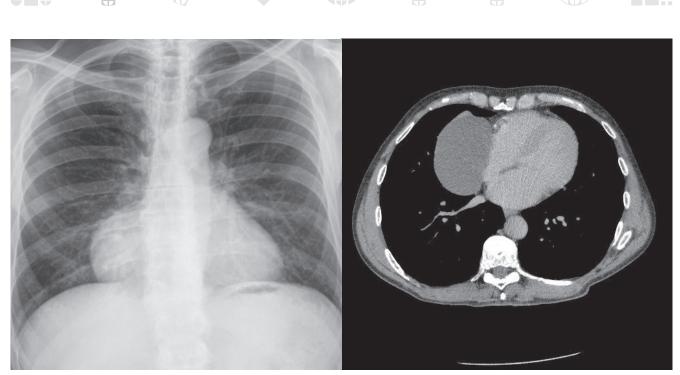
Left: Preoperative chest X-ray; Right: Preoperative CT chest scan of the patient
